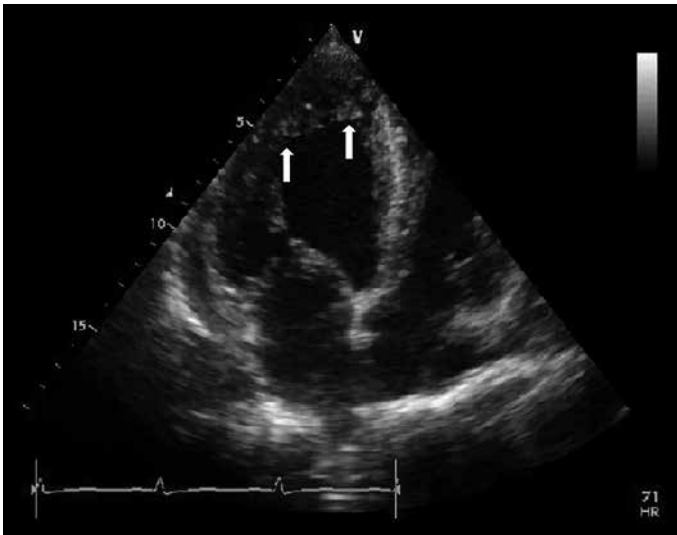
Transthoracic echocardiography of the patient revealing prominent trabeculations and intertrabecular recesses in the left ventricle
